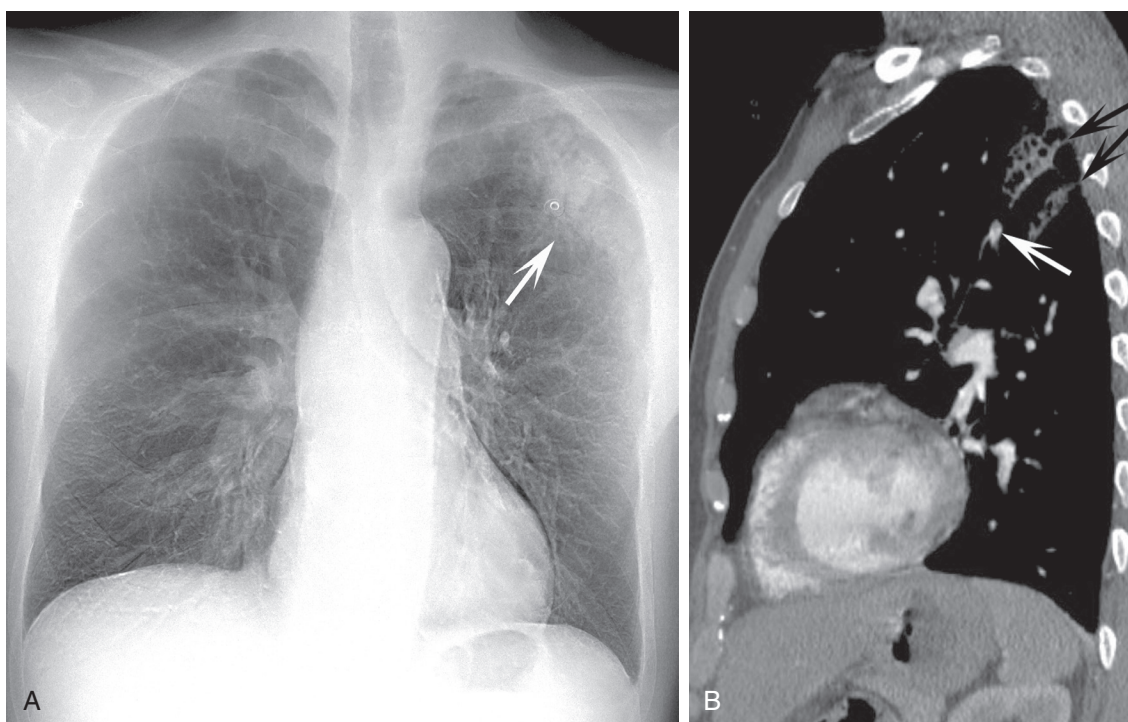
■ A, Posteroanterior (PA) upright chest x-ray. Peripheral wedge-shaped opacity in the left upper lobe (*white arrow*). B, Sagittal computed tomography (CT) reconstruction. CT in same patient showing left upper lobe infarct and hemorrhage (*black arrows*) with an embolus in the left upper lobe segmental artery supplying this region (*white arrow*).
